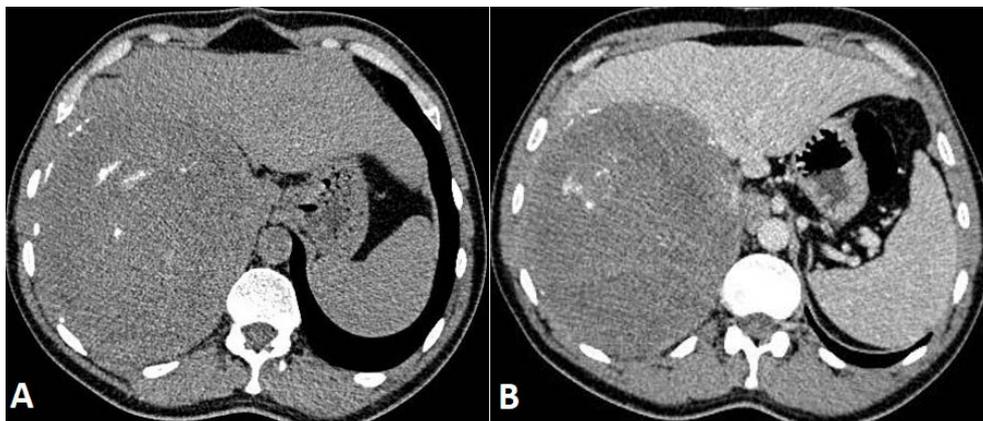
CT showing a voluminous right adrenal mass of tissue density, containing peripheral and central calcifications in places with heterogeneous zones. (A: before injection, B: after injection)
